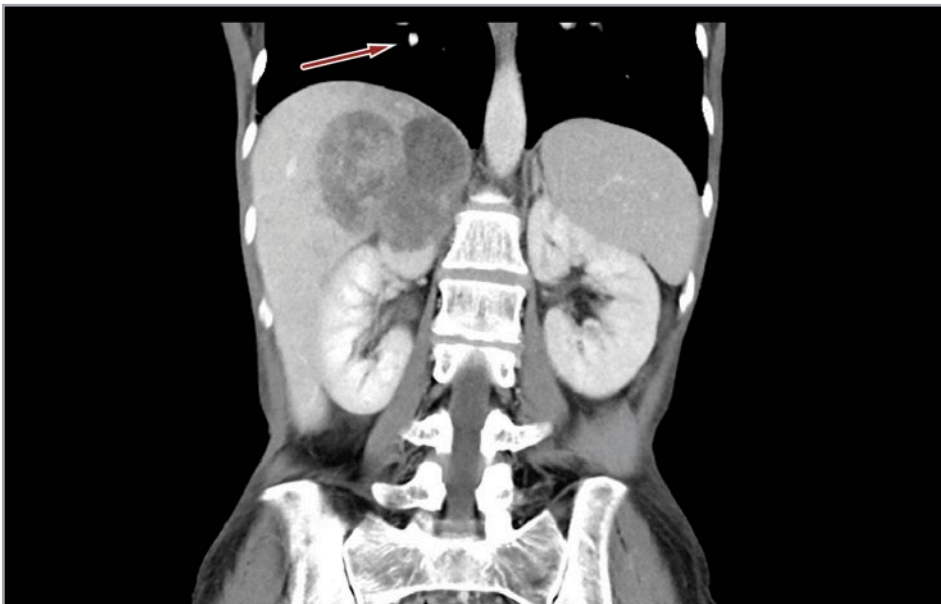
CT scan showing evidence of lung metastasis (red arrow) in right pulmonary lobe (ten days after hospital admission)
